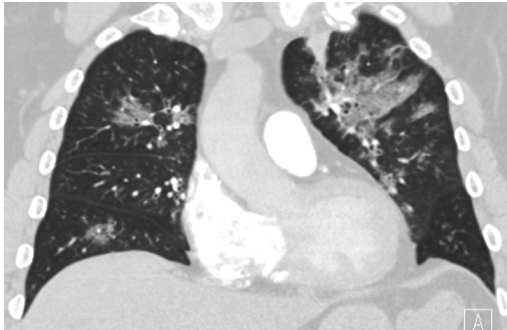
Bronchopneumonia caused by H3N1 influenza A in a 66-year-old man. Coronal chest CT demonstrates bilateral peribronchovascular ground-glass opacities with interlobular septal thickening.
